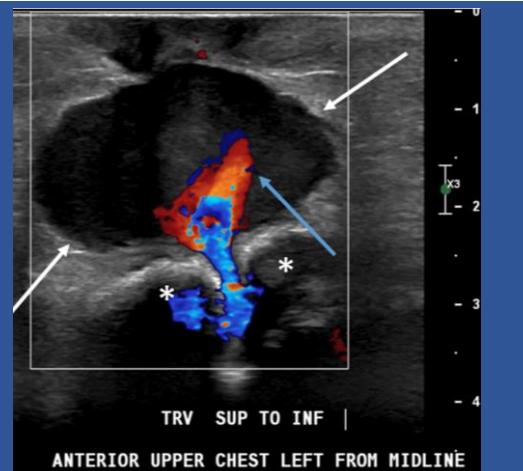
Transverse Doppler ultrasound image performed at the patient's site of concern labeled the upper chest to the left of midline. Round, well circumscribed hypoechoic focus (white arrows) just beneath the skin surface with pulsating Doppler flow (blue arrow) along its inferior aspect – emanating from the beneath the sternum (asterisks).
